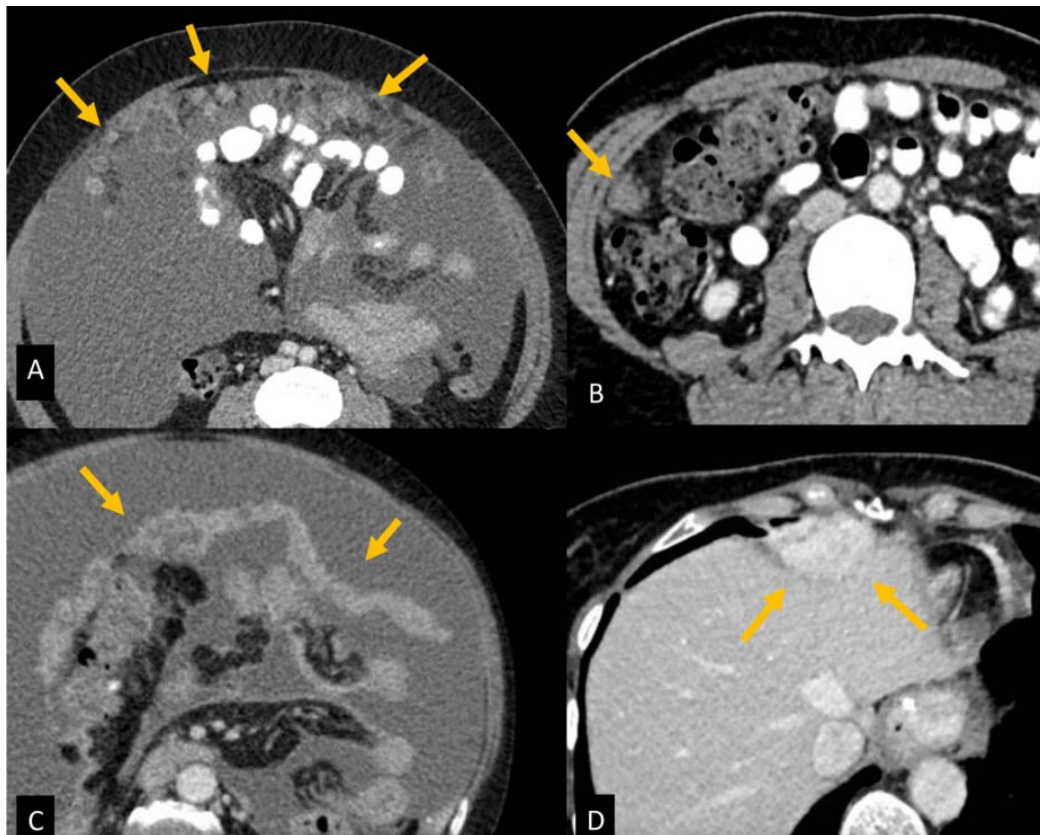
Examples of different types of peritoneal carcinomatosis involvement according to its morphology (abdominal CT images with intravenous and oral contrast in A and B). A) Multiple nodules in the greater omentum. B) Nodule in the right paracolic gutter. C) Plaque-like tumour deposits in the greater omentum and D) Plaque-like tumour deposits in the perihepatic region
